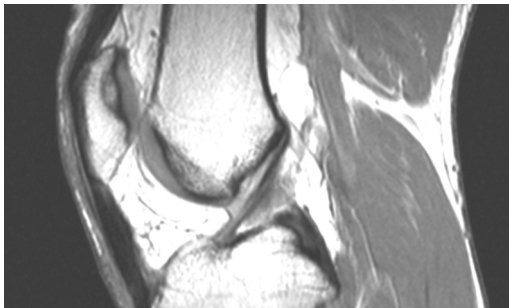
Magnetic resonance imaging of a normal anterior cruciate ligament.
